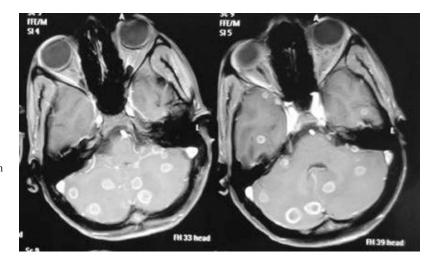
MRI brain with contrast revealed concurrent multiple intracranial tuberculomas in patient with spinal intramedullary tuberculoma
